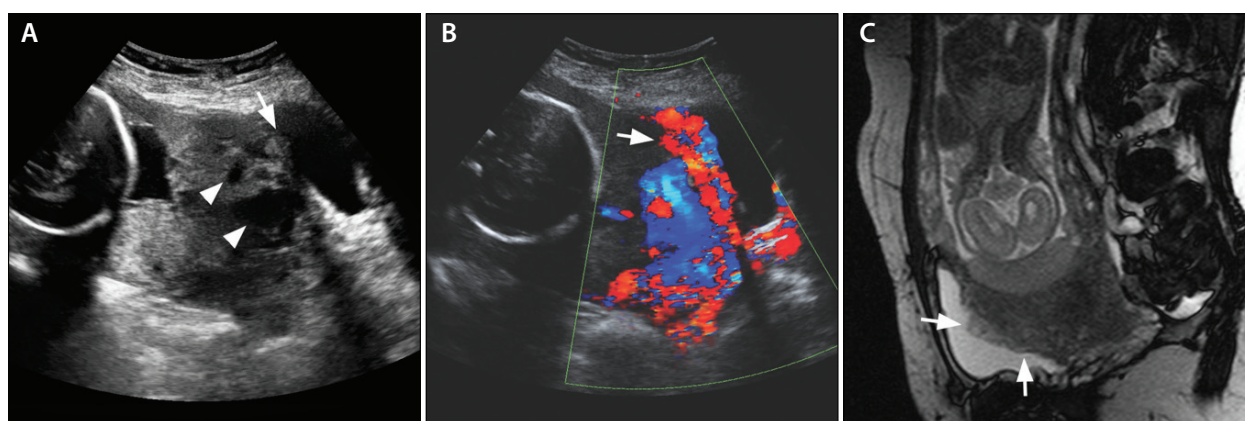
A 38-year-old woman with imaging diagnosis of placenta percreta. Ultrasound image shows hypoechoic placental lacunae (arrowheads) and loss of the myometrial-bladder interface with protrusion into the bladder wall (arrow) (A). A color Doppler ultrasound image shows abnormal blood vessels at the myometrium-bladder interface (arrow) and flow within the placenta lacunae (B). Sagittal T2-weighted MRI image shows a heterogeneous-appearing placenta with uterine bulging, tenting of the urinary bladder, and invasion into the bladder (arrows) (C).
